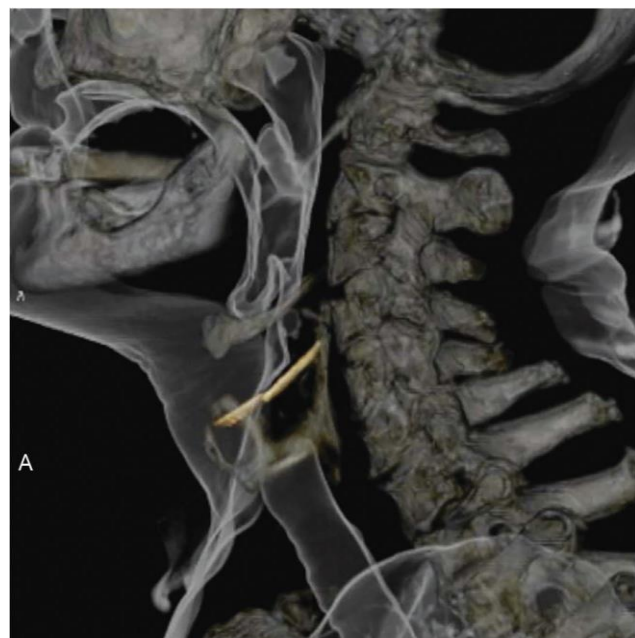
Multiplanar reformatting computed tomography shows penetration of the larynx by the foreign body.
